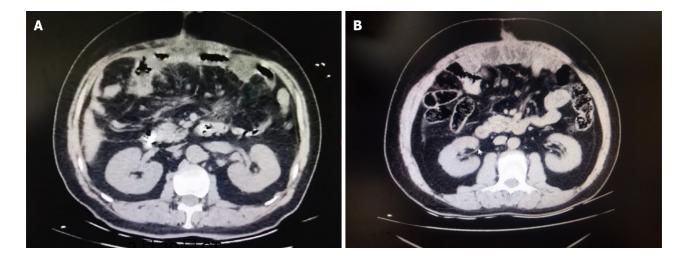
Abdominal computed tomography showed a significant alleviation of intestinal obstruction following methylprednisolone treatment. A: After 1 week of methylprednisolone treatment, there was a marked reduction in the intestinal obstruction; B: 8 months after methylprednisolone treatment.
